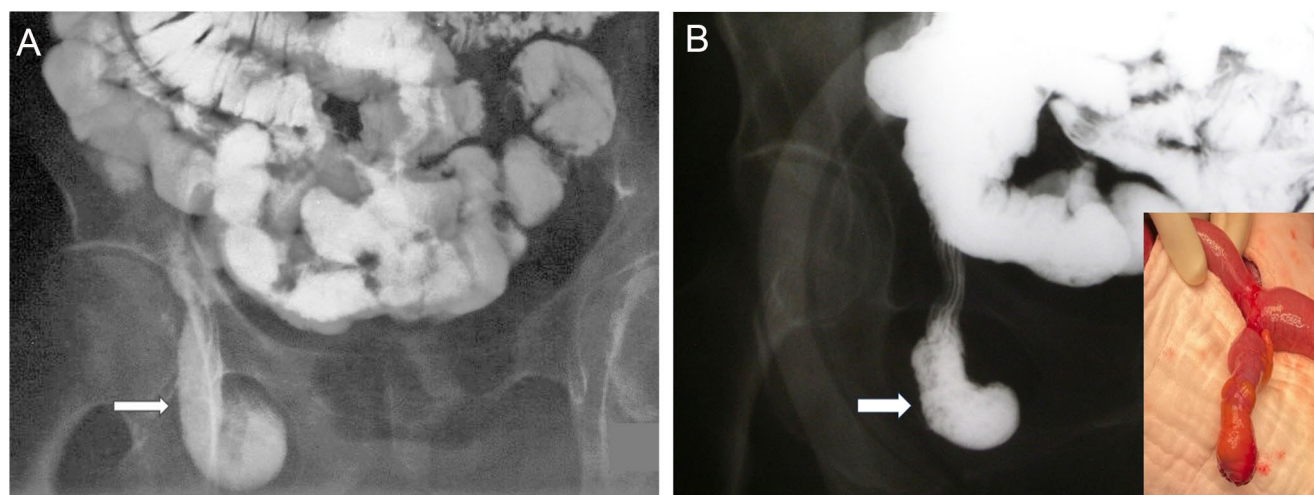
A Radiograph from small bowel series of this 34-year-old man presenting with a painful groin mass demonstrates a 7 cm elongated Meckel's diverticulum with bulbous appearance of its distal part within the right inguinal hernia (arrow). B Spot film obtained during
